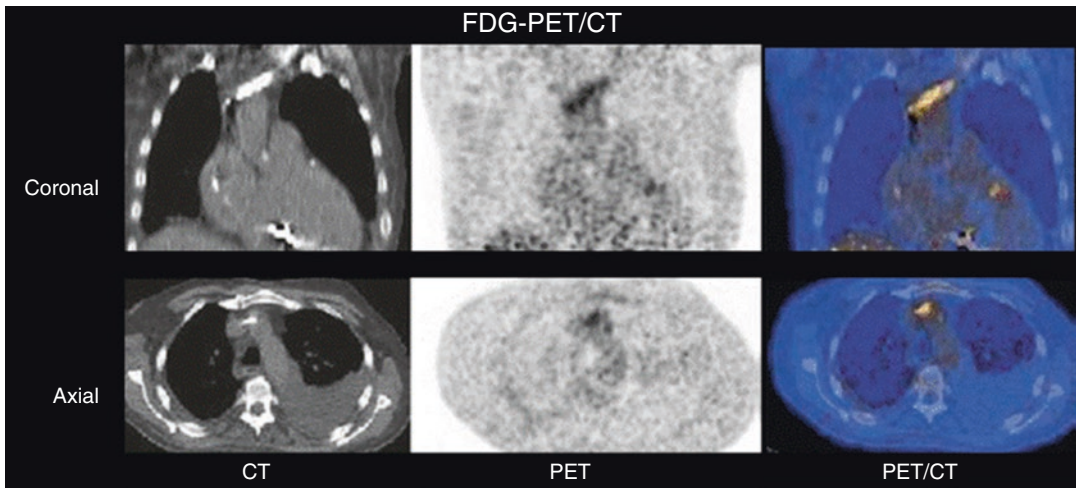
FDG PET/CT study for a 68-year-old male with bacteremia and questionable infectious endocarditis. There is increased FDG accumulation around electrode in the left subclavian vein near superior vena cava. Findings
